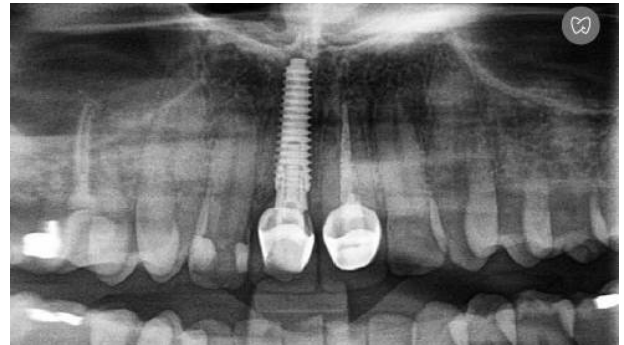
Post OP Radiograph
